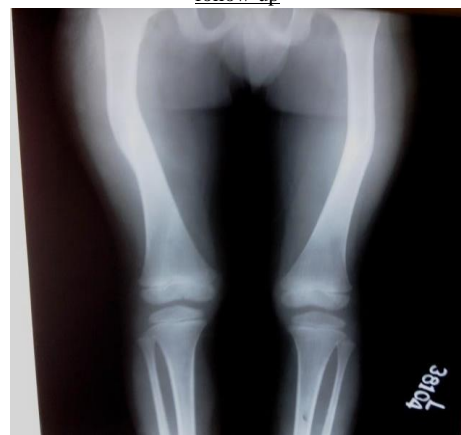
Radiograph of bilateral femur at 13 months follow-up showing radiological union
